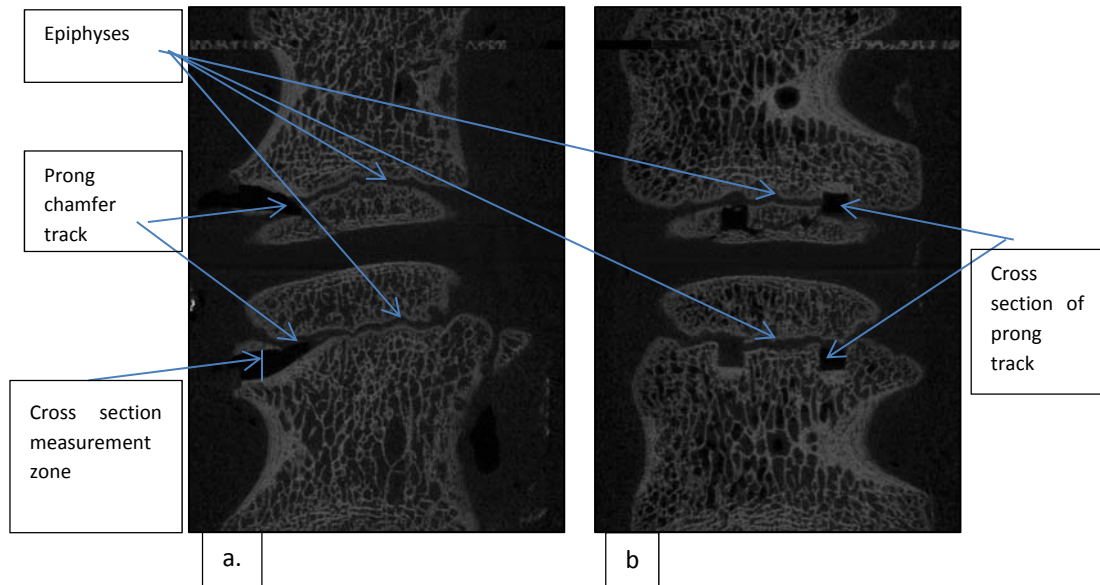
EXAMPLE OF MICRO CT OF A MOTION SEGMENT SHOWING EPIPHYSES AND STAPLE PRONG TRACKS. a. LONGUTUDINAL SECTION THROUGH PRONG TRACK. b. CROSS SECTION THROUGH PRONG TRACK AT THE MEASUREMENT ZONE.
